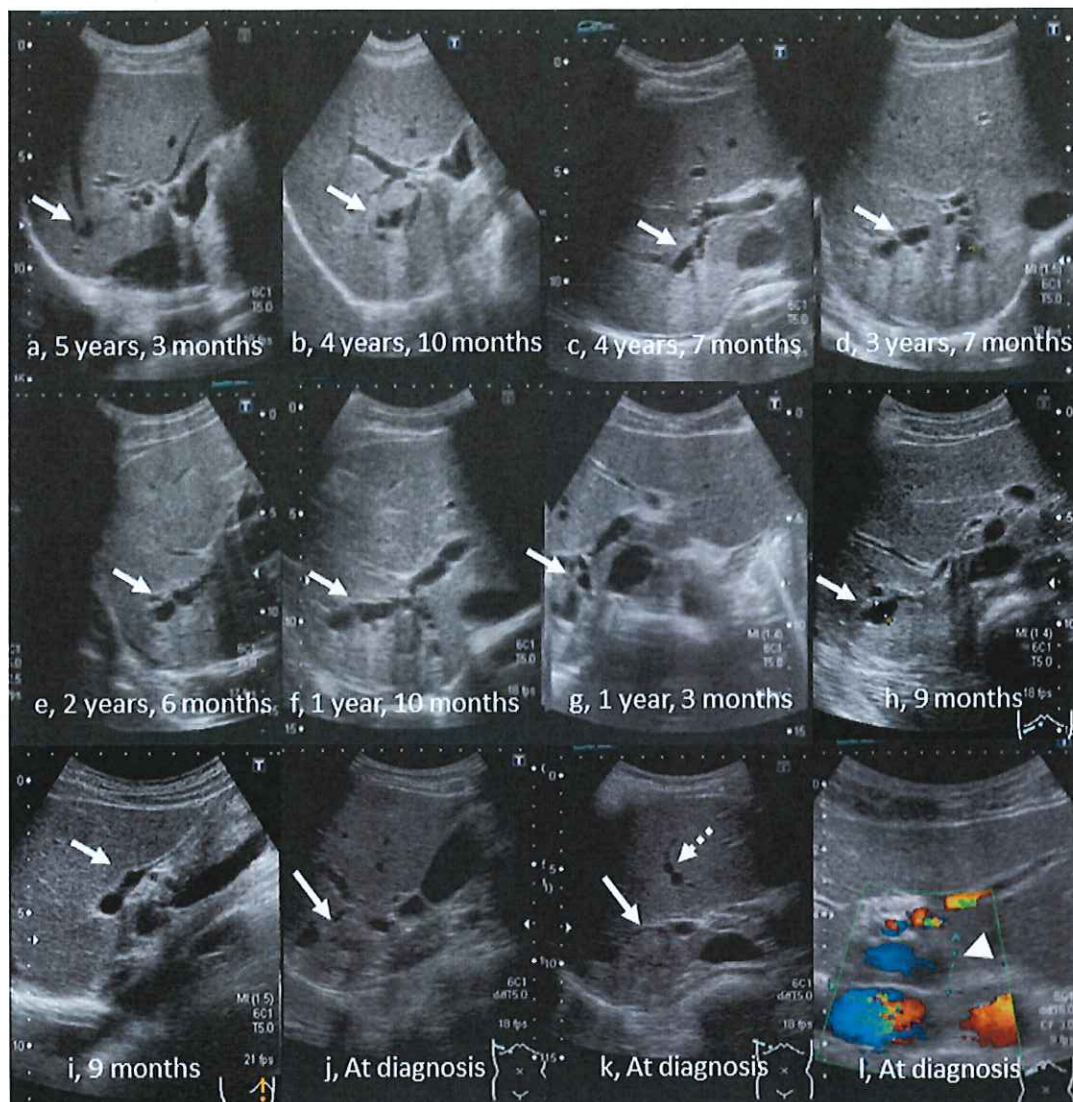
The changes in the findings of abdominal ultrasound studies before the diagnosis of cholangiocarcinoma in patient 6. The times indicate the duration before the detection of cholangiocarcinoma. Short arrows show the regional dilatation of the bile ducts without
